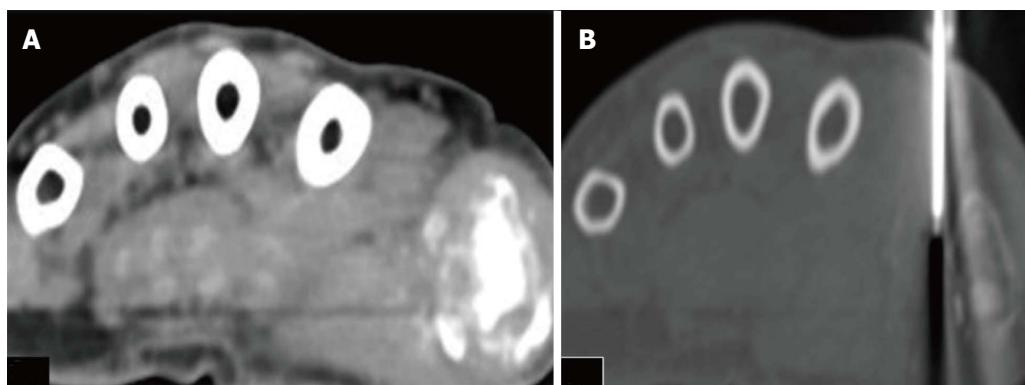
Axial computed tomography of the hand. The patient is positioned in prone position. A: Axial CT scan image in soft tissue window; B: Axial CT scan image in bone window is showing Trucut biopsy needle taking tissue sample from the soft tissue component surrounding the area of lytic destructive lesion at the first metacarpo-phalangeal joint. CT: Computed tomography.
